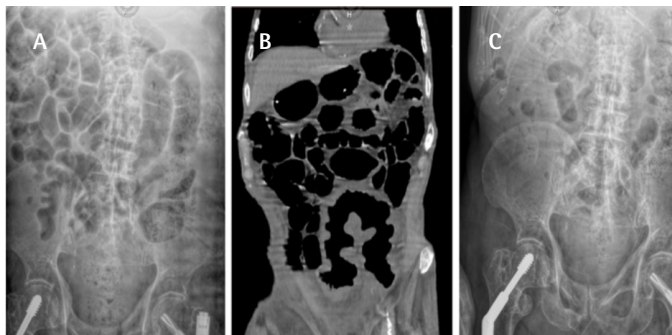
A) Abdominal X-ray revealed intestinal occlusion in the descending colon and sigmoid colon with 10 cm dilation. B) Abdominal computed tomography scan, which exhibited an intestinal occlusion in the sigmoid colon. C) Abdominal X-ray after "Mayo enemas" with remarkable improvement
